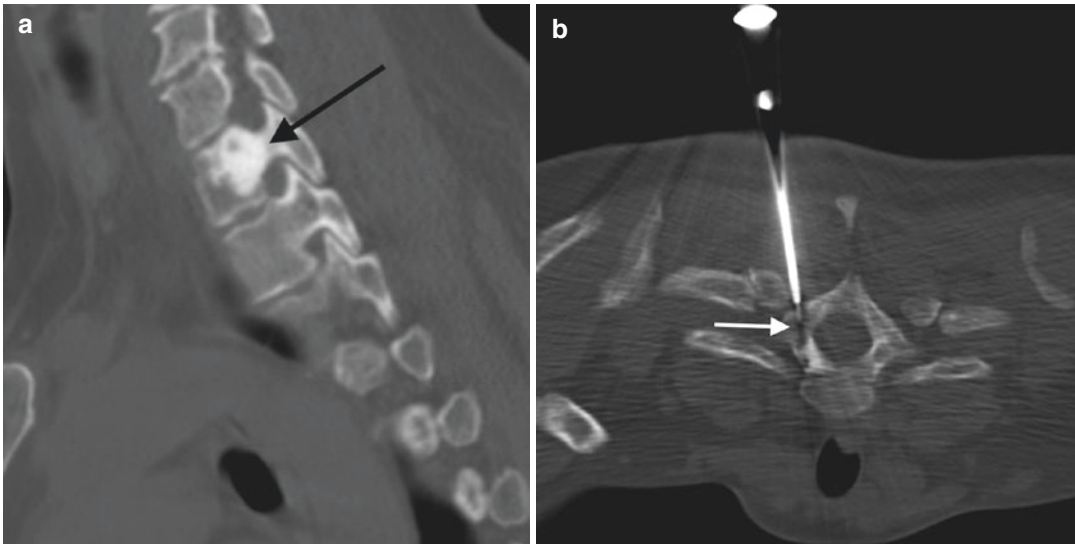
A 50-year-old female. Reformatted parasagittal CT image (a) shows well-defined sclerotic lesion within the posterior T1 vertebral body and pedicle (arrow). Axial
